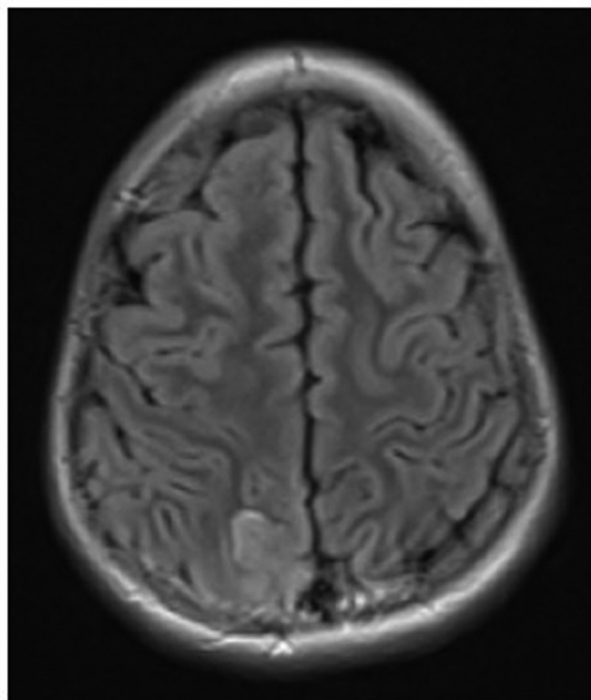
MR imaging T2/FLAIR status post tonic-clonic seizure. MR = magnetic resonance.
